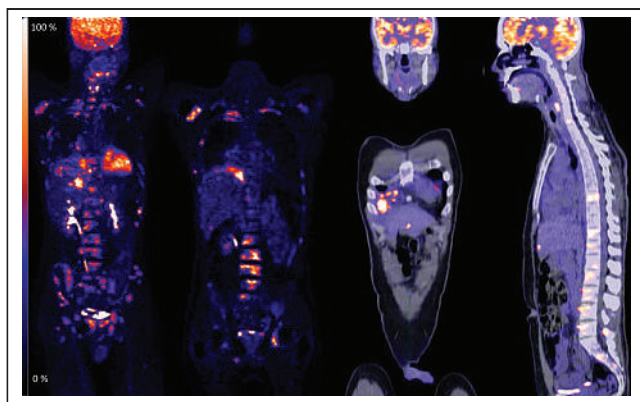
^{18}F -FDG PET scan showing diffuse bony lesions but also detecting pleural and very minimal subtle liver disease not visualized on ^{68}Ga -DOTATATE scan. From right to left maximum-intensity-projection PET, coronal PET, coronal PET/CT, and sagittal PET/CT images.
